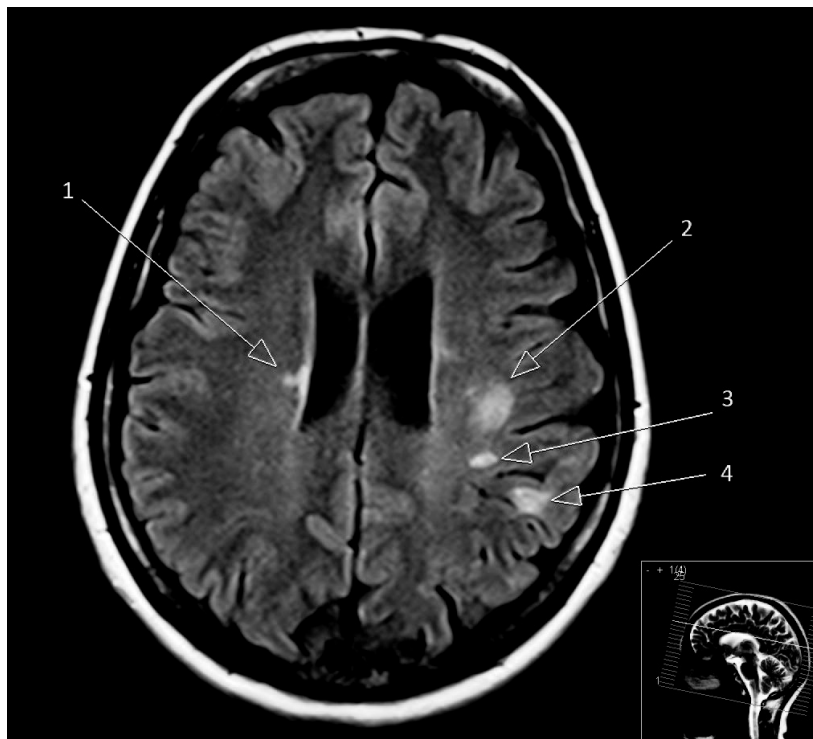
Axial fluid-attenuated inversion recovery-weighted brain MRI with lesion localization:
